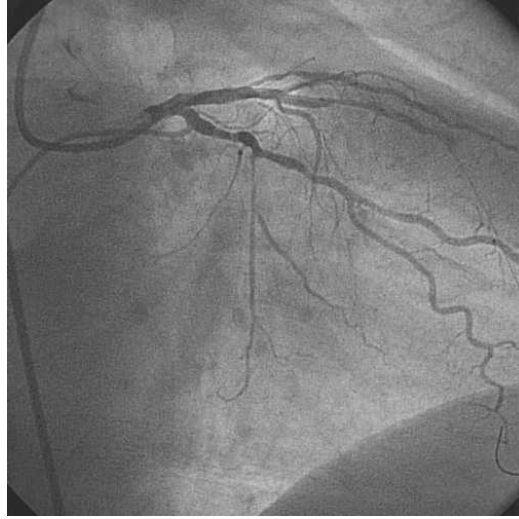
Diagnostic x-ray image. The coronary arteries filled with radio-opaque contrast dye are visible in x-ray. (Image courtesy of Catharina Hospital Eindhoven)
